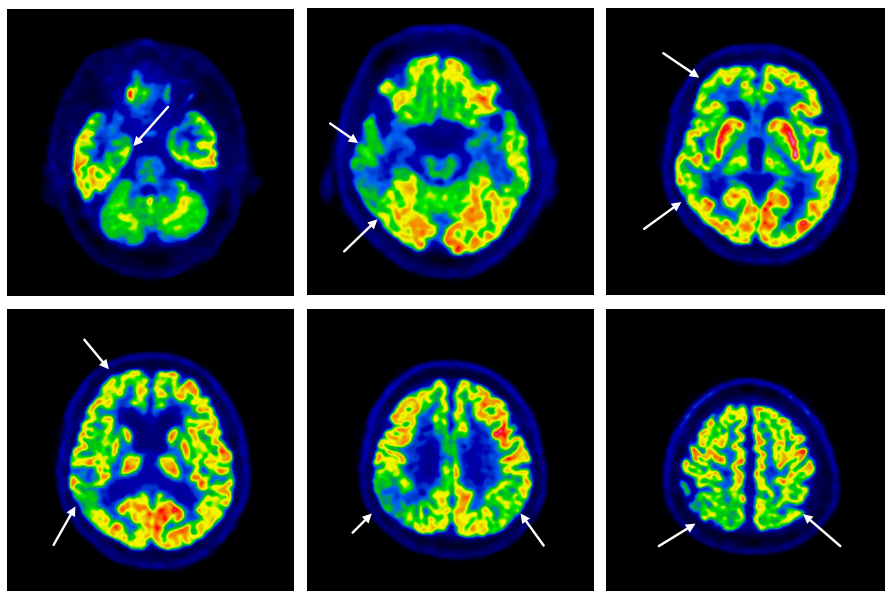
MCI case. BresTome FDG-PET axial image from cerebellum to thalamus–basal ganglia level. Right-dominant cortical hypometabolism is clearly depicted (→).
